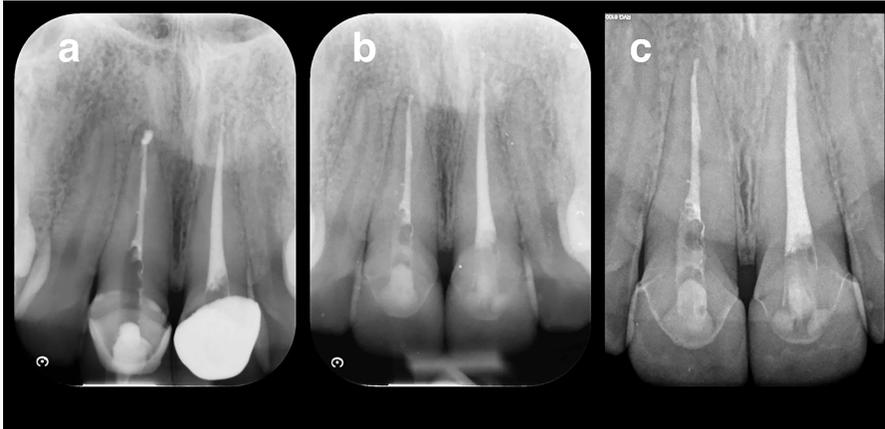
a) treatment confirmed with radiograph b) one-year follow-up confirmed with periapical radiograph c) two and half years follow-up confirmed with periapical radiography
